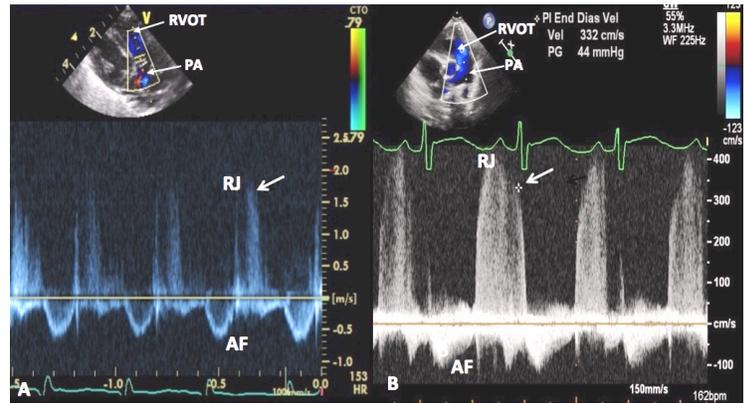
A. Pulse Doppler recording in the parasternal short axis view as shown in the insert at the top demonstrating pulmonary valve regurgitant jet (RJ). This is low (arrow) (1.6 m/s), suggesting low pulmonary artery pressure (See the text for further discussion). B. Continuous wave Doppler recording in the parasternal short axis view as shown in the insert at the top exemplifying high pulmonary valve RJ (arrow) (3.3 m/s). This high velocity indicates high pulmonary artery pressure (See the text for further clarification). AF, antegrade pulmonary flow. PA pulmonary artery, RVOT, right ventricular outflow tract.
